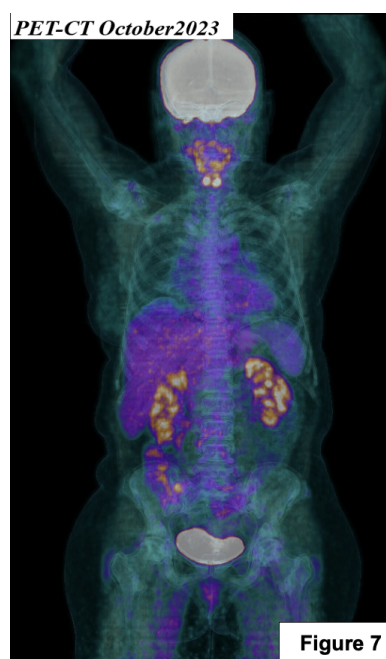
PET-CT with maintenance of complete metabolic response.
